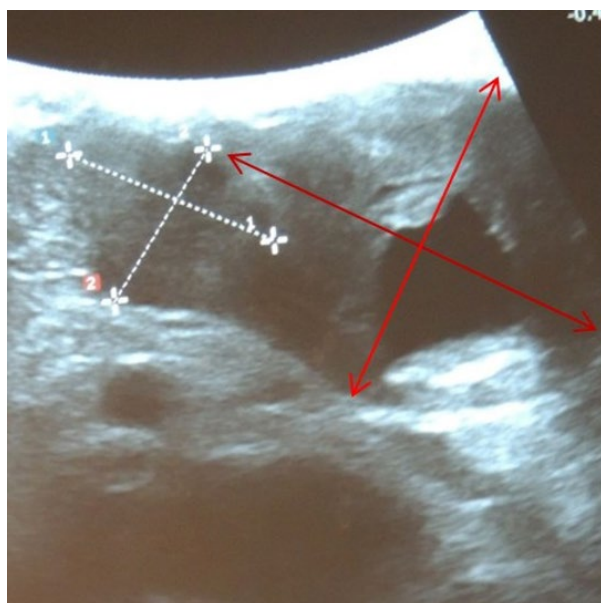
Intraoperative data obtained during the second electroporation session. Data from intraoperative ultrasound – the area of the previous electroporation up to 5 cm – marked with red arrows, and next to it, the area of recurrence up to 1.5 cm, the boundaries are marked with a dashed line.
